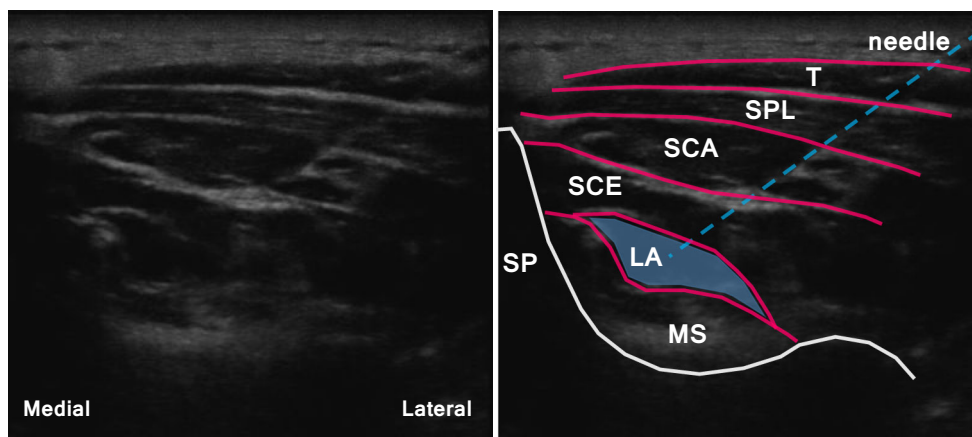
Figure Ultrasonography transversal view of multifidus cervicis plane block visualized at the level of the fifth cervical vertebra. A local anesthetic was injected into the fascial plane between the multifidus cervicis and semispinalis cervicis muscles. LA = local anesthetic;
